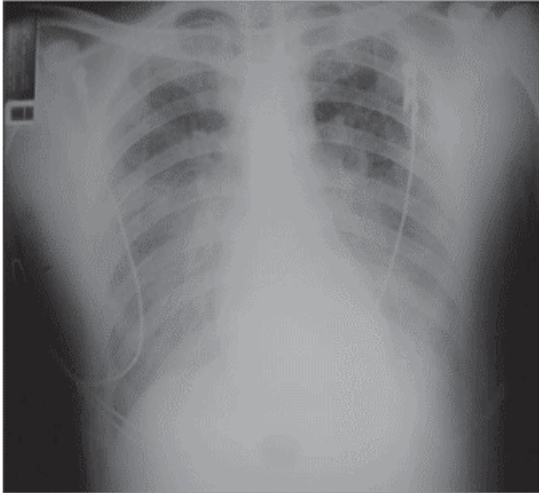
Chest radiograph showing improved ventilation in the upper lobes of the lungs after CPAP at 15 cm H₂O
